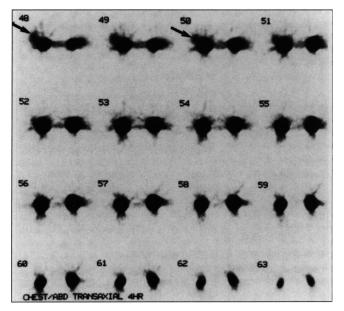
SPECT scan obtained 4 hr postinfusion of 30 mCi ^{99m}Tc-CEA-Scan[®] in a patient with occult colon cancer (negative CT). Transverse slices clearly showed a liver lesion in the posterior segment of the right liver lobe (arrow) despite the intense uptake of the right kidney. Liver metastasis was confirmed by surgery.
